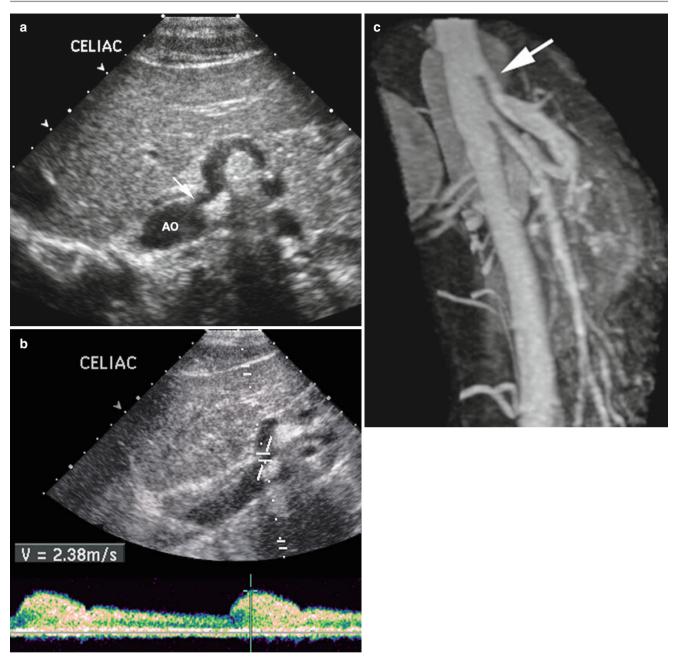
Celiac artery stenosis. (a) Transverse sonogram demonstrating stenosis (*arrow*) at the origin of celiac artery from the aorta. (b) Sagittal midline image of celiac origin from aorta with spectral Doppler
